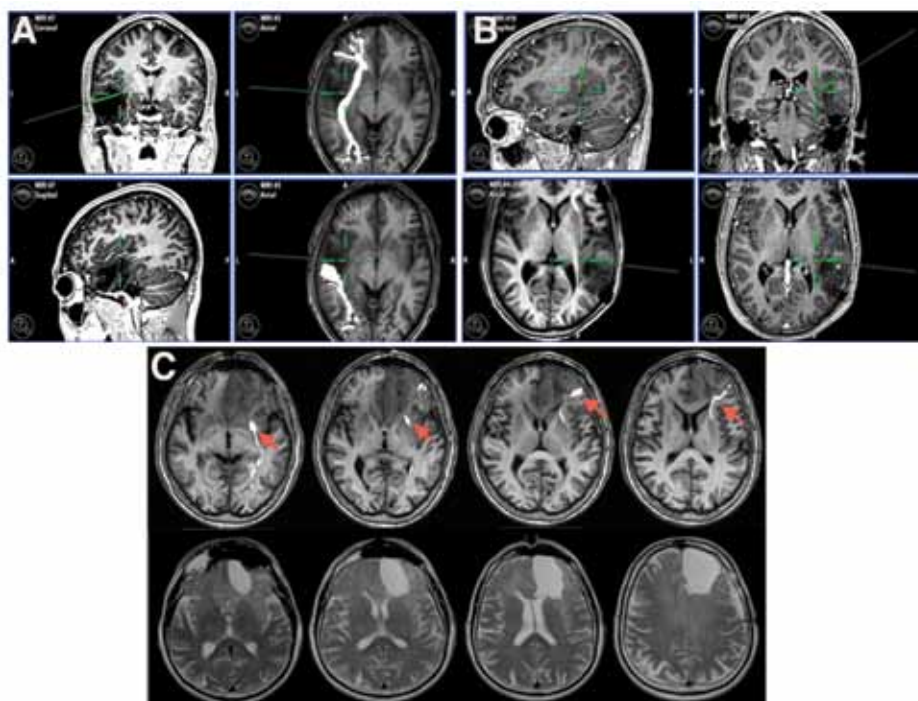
Diffusion tensor imaging–FT reconstruction of the IFO. A and B: Cases of low-grade temporal oligodendrogliomas. Diffusion tensor imaging–FT reconstruction of the IFO was fused with postcontrast T1-weighted MR images and loaded into the neuronavigation system. The IFO, shown as a *highlighted bright white ROI*, was located at the superior medial border of the tumor, where DES evoked semantic paraphasias (DES sites were located at the center of the *green cursors*). C: A case of a left frontal oligodendroglioma. Diffusion tensor imaging–FT reconstruction of the IFO, which was merged with postcontrast T1-weighted MR images, showed that the tract was located at the posterior border of the tumor (upper panels, arrows). Postoperative T2-weighted MR images showed that the resection margins coincided posteriorly with the location of the IFO as shown by DT imaging–FT (lower panels).
